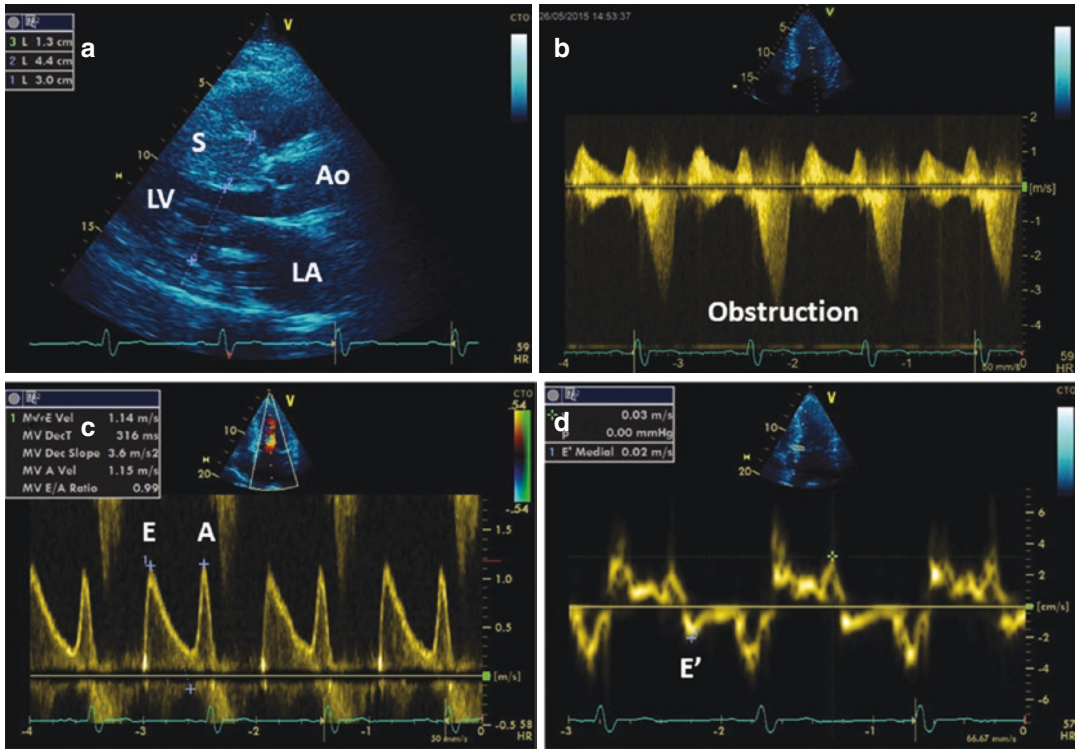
Hypertrophic cardiomyopathy with left ventricular (LV) obstruction. (a) Parasternal long axis view with septum hypertrophy; (b) left ventricular obstructive flow recorded using continuous wave Doppler; (c) Mitral flow; (d) mitral annulus velocities recorded using tissue
